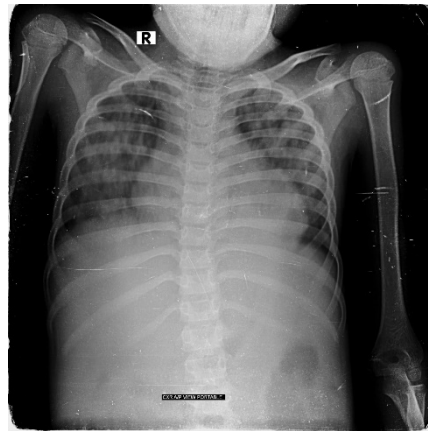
Chest X-ray: Suggestive of pulmonary oedema
